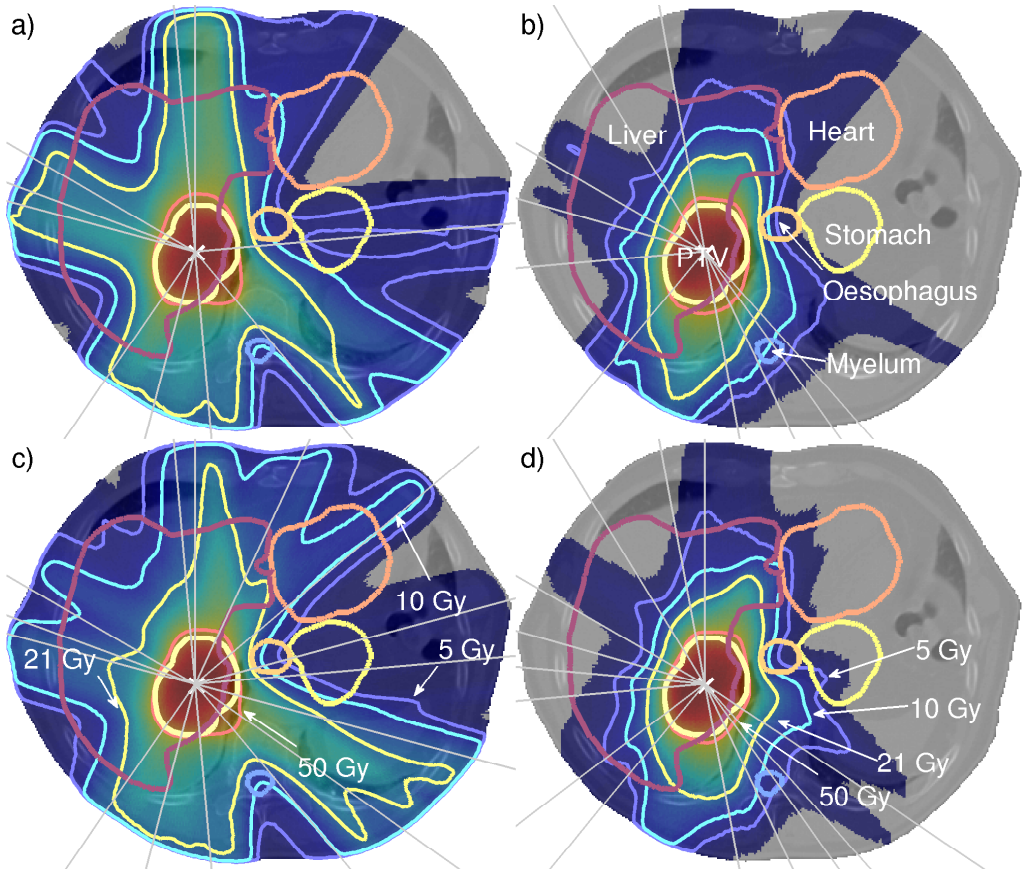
Axial CT-slice of the liver case with dose distributions and beams. a) and b): 10 beam optimized coplanar and non-coplanar plans respectively. c) and d) 15 beam optimized coplanar and non-coplanar plans respectively. For the non-coplanar setups, projections of the selected beams on the axial slice are displayed.
